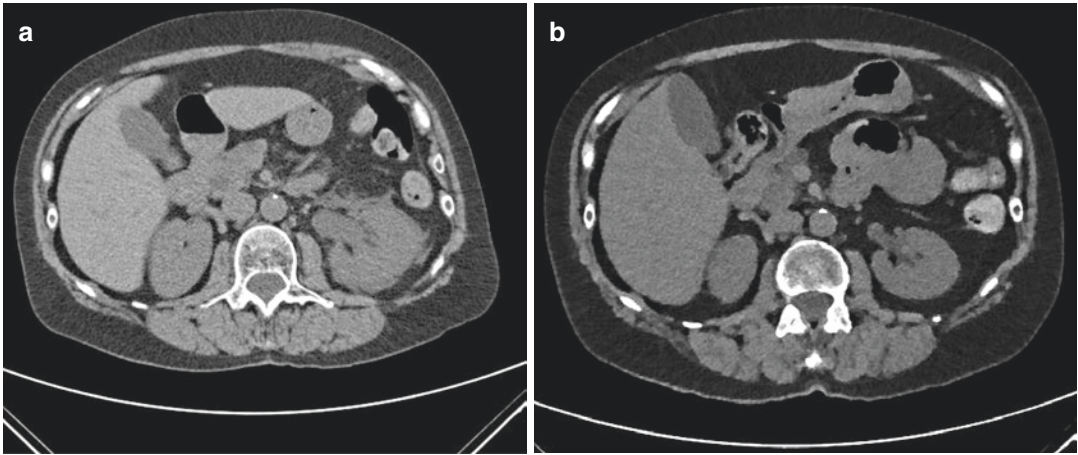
Non-contrast CT of the abdomen showing left sided collecting system dilation with perinephric stranding in the panel on the left (a). On the right (b), CT shows resolution following relief of obstruction
